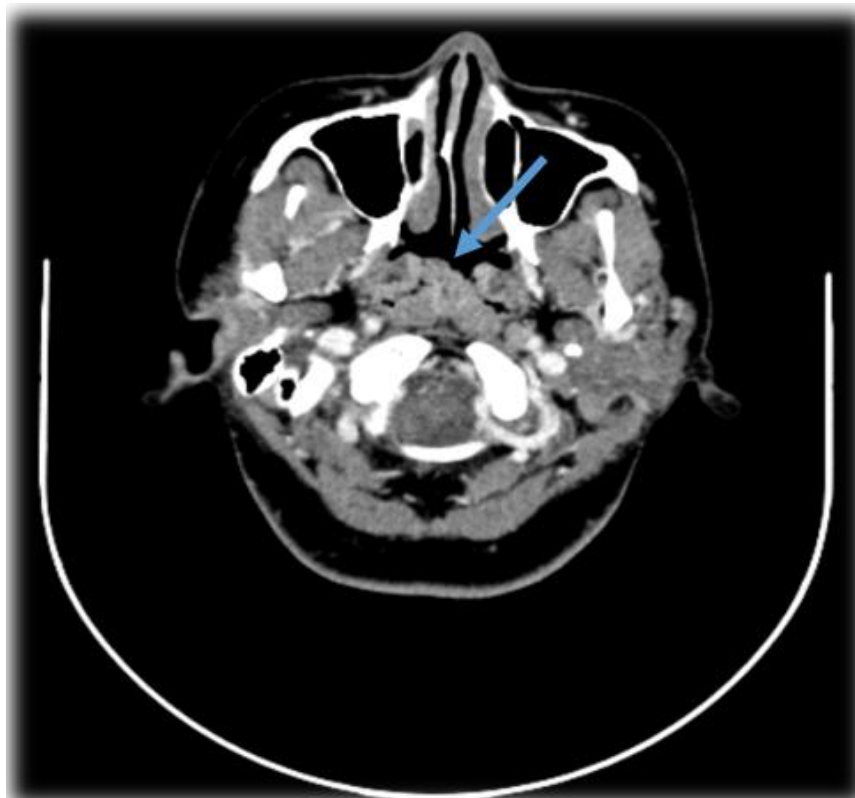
Contrasted CT showing the postnasal space pre-treatment
